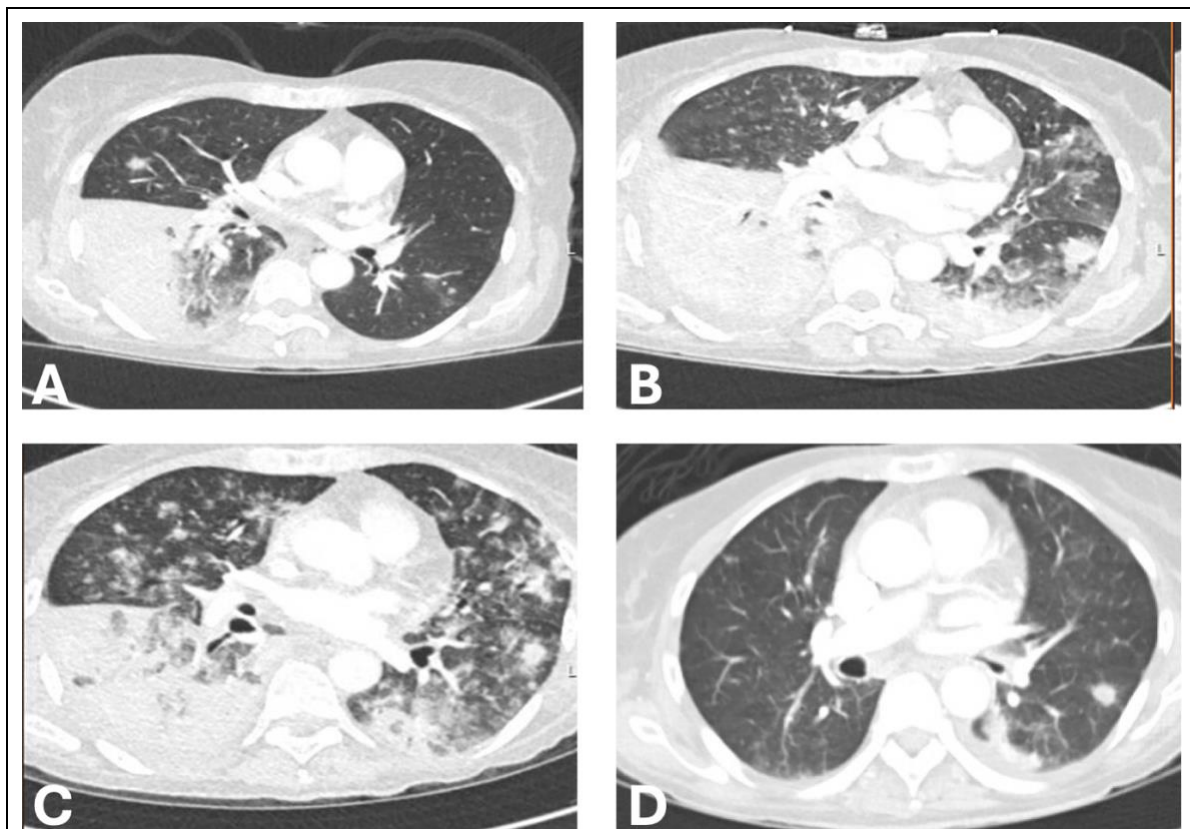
CT Chest Imaging showing progression of lung opacification over time.
